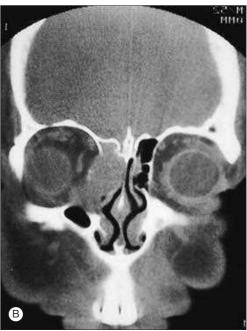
Tearing Secondary to Neoplasm. (A) Patient with right-sided tearing and a mass at the inner canthus. The system was fully patent to syringing. (B) Computed tomography scan in this patient demonstrates an ethmoidal orbital plasmocytoma with compression of the lacrimal sac.
